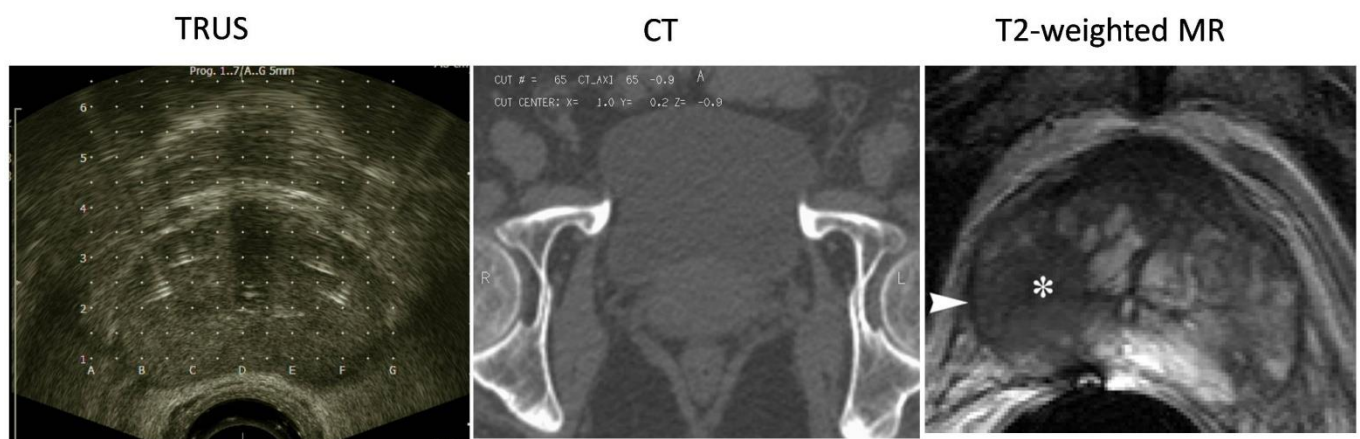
Comparison of the TRUS, CT, and MRI in prostate imaging. On the far right panel, depicting MRI, asterisk indicates cancerous lesion in the prostate and arrowhead indicates clearly distinguishable and defined prostate capsule (from ref. (147)).
